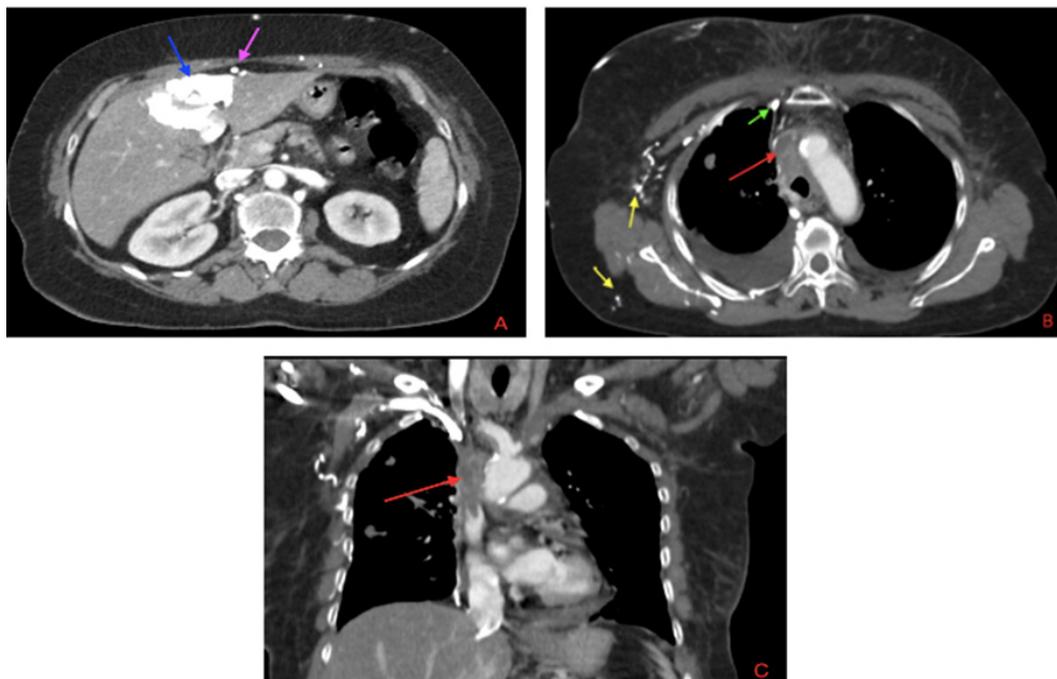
Contrast-enhanced chest CT with abdominal images in a patient under follow-up for invasive ductal breast carcinoma, presenting to the emergency department with "cape-like" upper body edema, demonstrating a hot spot sign secondary to superior vena cava (SVC) obstruction.
